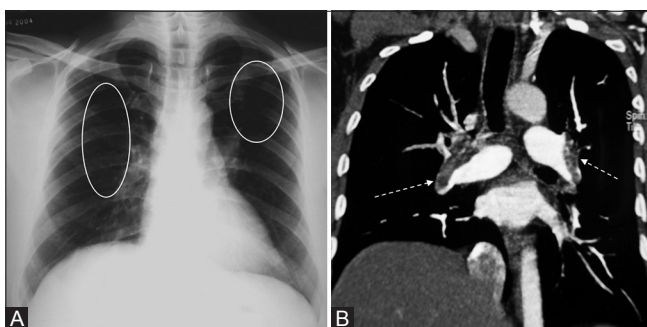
(A and B): Bilateral lucent areas (white circles) representing oligemia in a patient (A) with computed tomography (B) suggestive of bilateral pulmonary emboli (white interrupted arrows)
